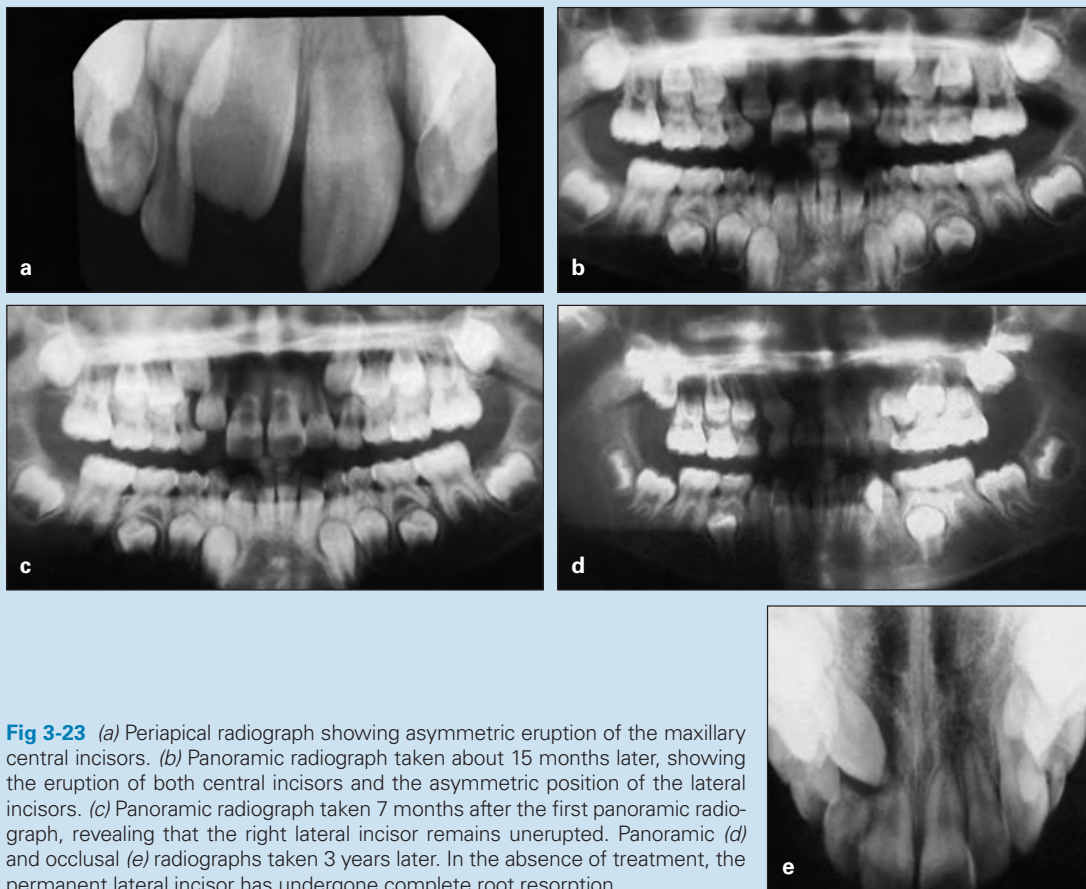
(a) Periapical radiograph showing asymmetric eruption of the maxillary central incisors. (b) Panoramic radiograph taken about 15 months later, showing the eruption of both central incisors and the asymmetric position of the lateral incisors. (c) Panoramic radiograph taken 7 months after the first panoramic radiograph, revealing that the right lateral incisor remains unerupted. Panoramic (d) and occlusal (e) radiographs taken 3 years later. In the absence of treatment, the permanent lateral incisor has undergone complete root resorption.
